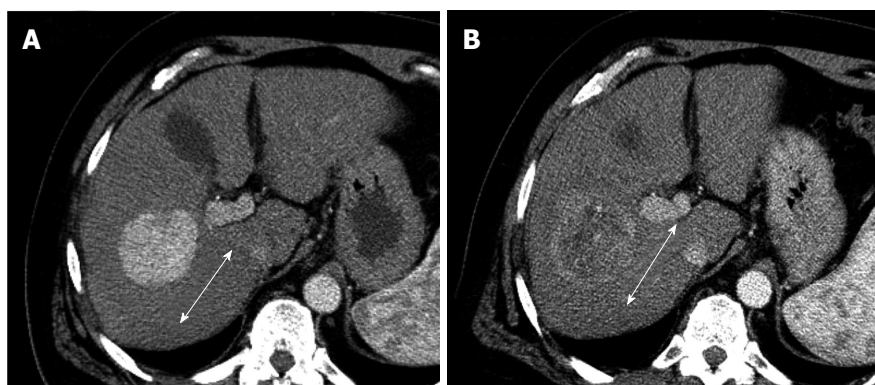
Portal-phase contrast enhanced diagnostic computed tomography of 58-year-old man with hepatocellular carcinoma. A: Baseline; B: Post treatment. Obvious tumor density change was observed after antiangiogenic treatment.
